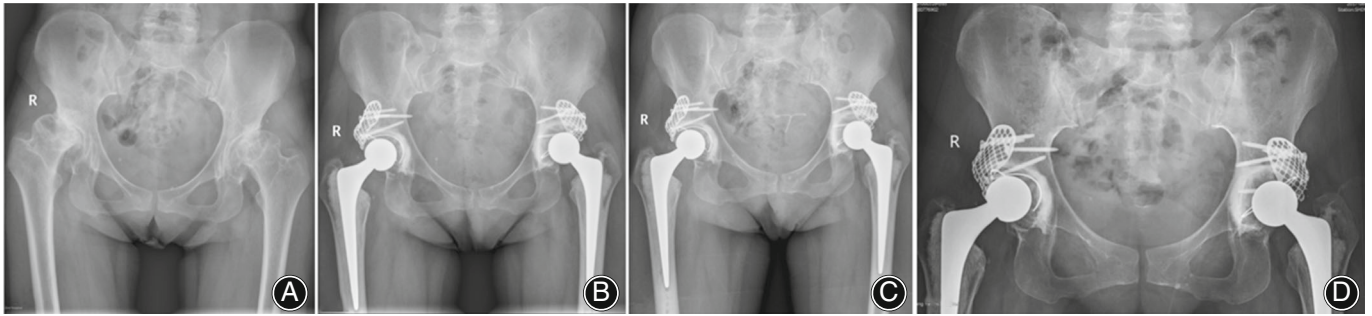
(A–D) Preoperative and follow-up radiographs of the bilateral hip joint in a 44-year-old woman. (A) The preoperative pelvic AP view of a female shows an acetabular defect on both sides. The 44 year-old female had bilateral DDH, which led to secondary hip osteoarthritis. (B) Radiography at 1 week after she received the second THR on the left hip and 10 months after the first surgery shows no radiographic loosening or cup migration. (C) Radiograph at 34 months after the first surgery on the right side and 24 months on the left side shows no radiographic loosening or cup migration. (D) Radiograph at 66 months after the first surgery on the right side and 56 months on the left side shows no radiographic loosening or cup migration.
